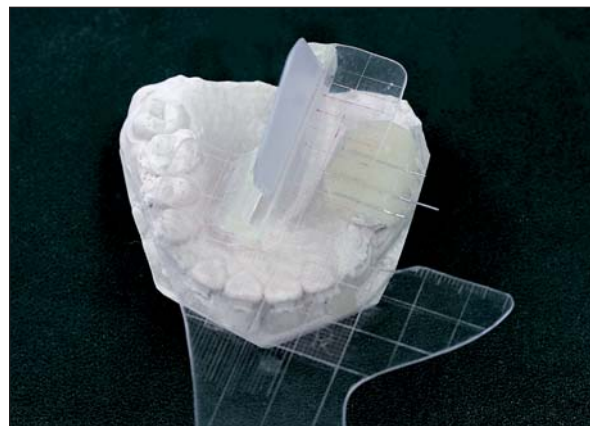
With the radiographic template in position, the film holder is adjusted so that 1 of the parallel lines is superimposed over 1 of the metal wires on the radiographic template.
